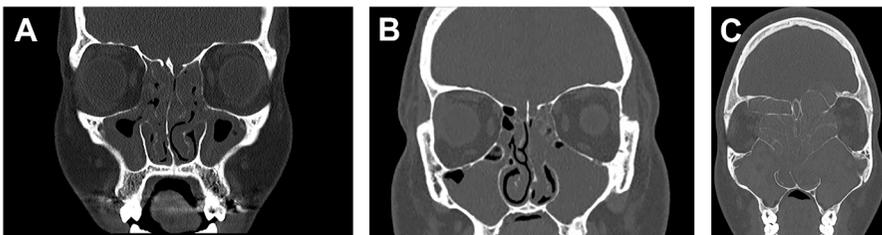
(A–C) Characteristic CT findings in CRS. (A) Mucosal thickening. (B) Sinus opacification. (C) Bony remodeling.
